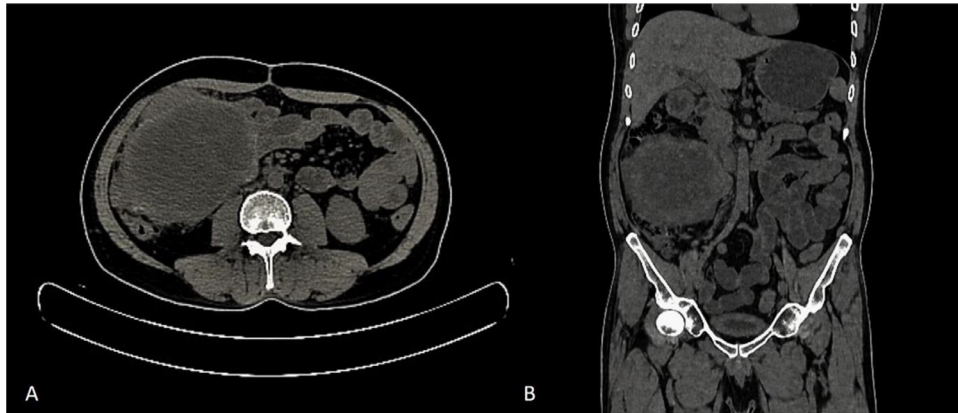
Primary malignant melanoma of the small intestine: noncontrast CT showing hypodense lesion with no evidence of intratumoral calcification or hemorrhage (A) axial (B) coronal.
